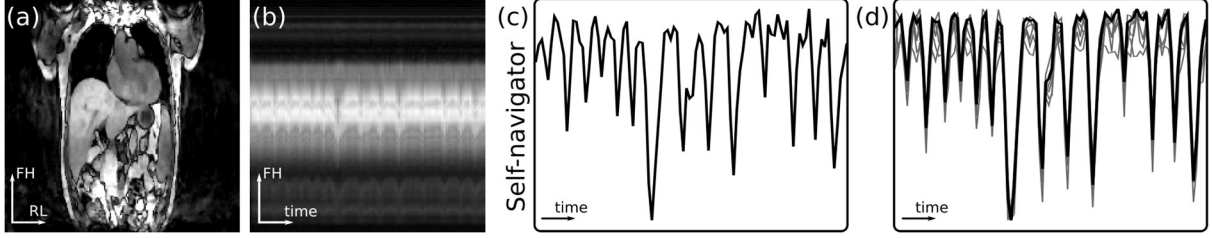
MR-based motion surrogate. (a) Coronal MR image. (b) 1D projection extracted from central k-space lines (i.e. $k_y = k_z = 0$) acquired repeatedly during data acquisition for a single coil. The foot-head (FH) motion of the heart and liver due to breathing can be clearly seen. (c) Respiratory self-navigator signal extracted as first principal component for one coil. (d) Self-navigator signals for all coils (grey lines) and first principle component from all coils (black line) which were then used as the final respiratory surrogate signal.
